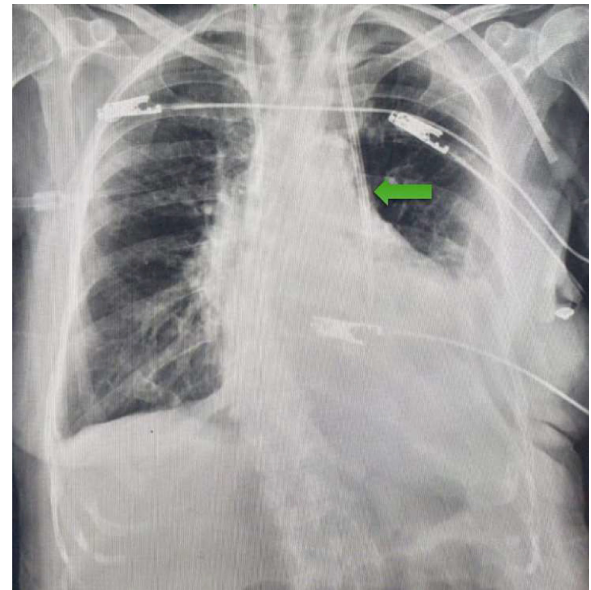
Chest X-ray show right sided central line (in the right SVC), Left perm Cath in the left sided SVC (green arrow). in addition to, Blunting of both costophrenic angles (more on the left side).
